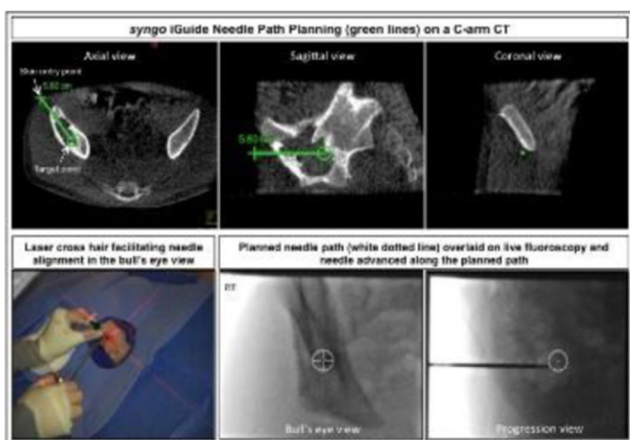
Needle path planning on a C-arm CT
